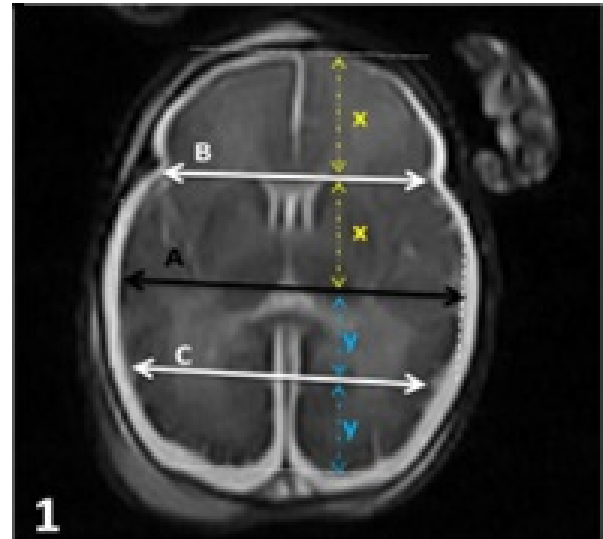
39 weeks of gestation age. axial cranium MR image obtained with T2-weighted sequence in a male fetus. A. right and left cerebrum hemisphere width. B. Anterior-middle width of the brain hemisphere. C. Posterior-middle width of the brain hemisphere.
